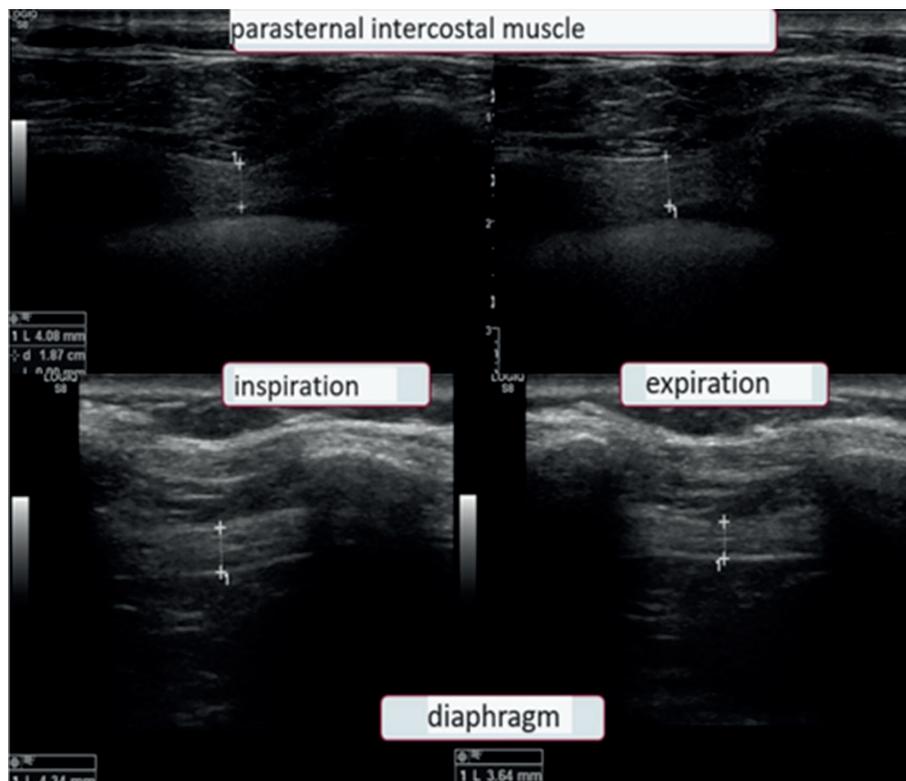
Diaphragm and parasternal muscle thickness measurements in inspiration and expiration.
